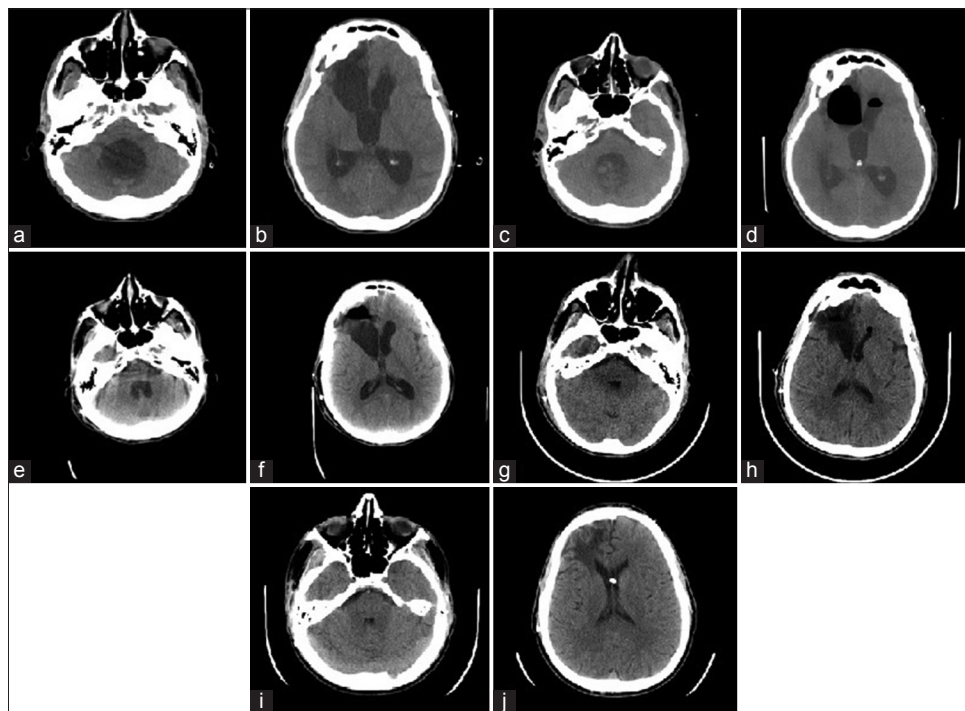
Axial computed tomography image showing ventriculomegaly of the fourth ventricle (a) and lateral ventricles (b) obtained 3 h prior to endoscopic third ventriculostomy/choroid plexus cauterization, with external ventricular drain positioned at 5 cmH_2O below midbrain. Computed tomography image obtained immediately following endoscopic third ventriculostomy/choroid plexus cauterization of the fourth ventricle (c) and lateral ventricles (d). Computed tomography image obtained 3 h prior to placement of ventriculopleural shunt, with external ventricular drain at 5 cmH_2O above midbrain, showing fourth (e) and lateral ventricles (f). Computed tomography imaging obtained on postoperative day 2 from shunting (g and h) and at 3 months neurosurgical follow-up (i and j)
